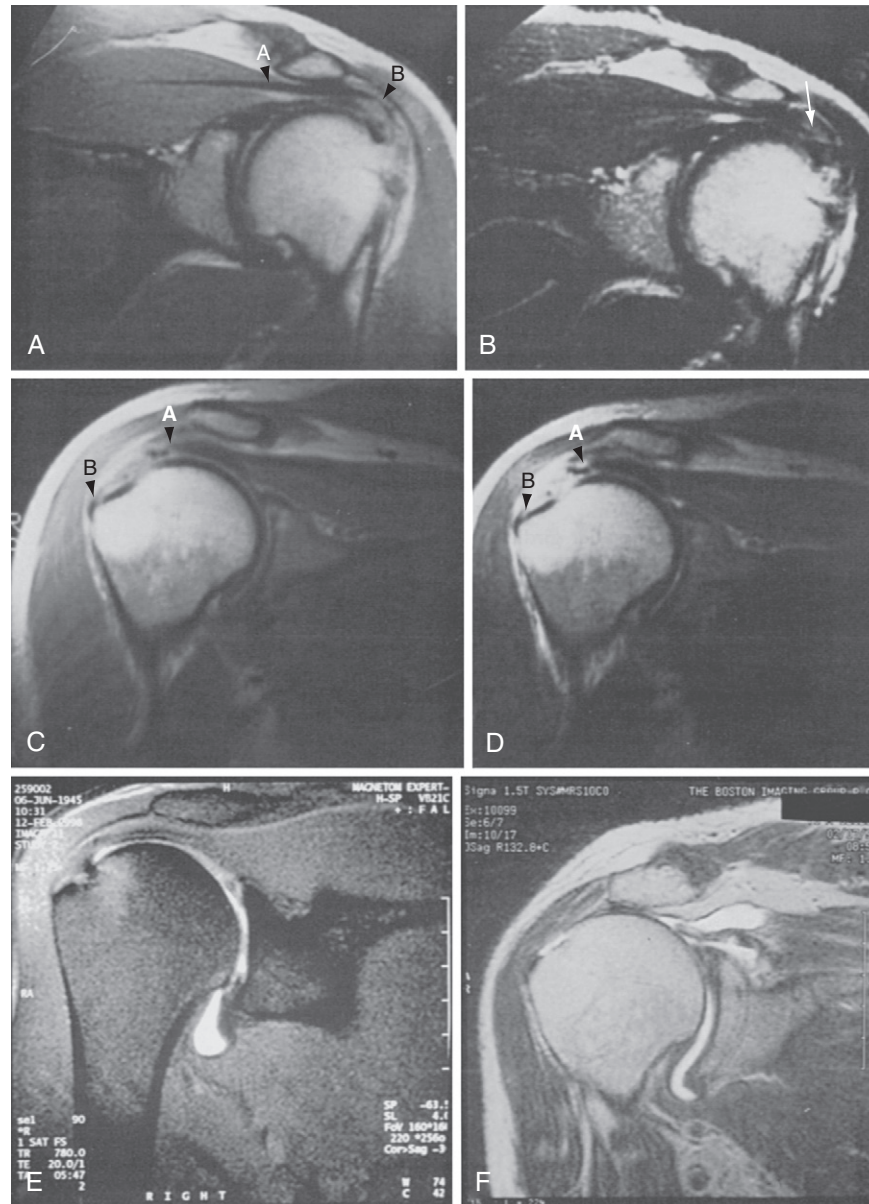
A, Magnetic resonance imaging (MRI) proton density-weighted coronal view shows the supraspinatus tendon as a black band (A) that has an increased signal as it nears insertion on the greater tuberosity (B). B, Similar view in a T2-weighted image shows increased signal as gray (arrow), indicating a partial-thickness tear or tendinitis. C, MRI proton density-weighted coronal view shows abrupt end of supraspinatus tendon as it courses right to left (A). From A to B is an area of increased signal followed by a short portion of tendon (B) inserting at the greater tuberosity. D, Similar view in a T2-weighted image shows increased signal as white (fluid density), indicating fluid in the gap of a complete rotator cuff tear. E, MR arthrography shows a normal rotator cuff. F, MR arthrography shows a chronic cuff tear with retraction.
